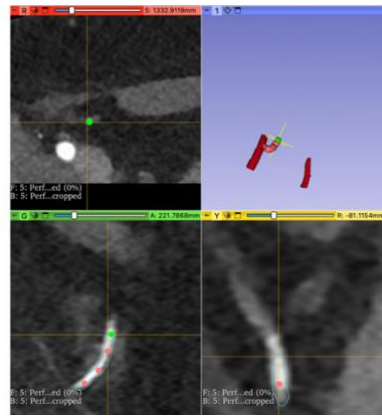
Screenshot of 3D Slicer scene for manual deep inferior epigastric artery segmentation using the "Draw tube" effect to segment the vessel. In the views the axial, coronal, and sagittal computed tomography angiograms respectively. In the upper right view, the 3D view of the marker points. The red dots are marker points; The blue lines indicate the tube path.
